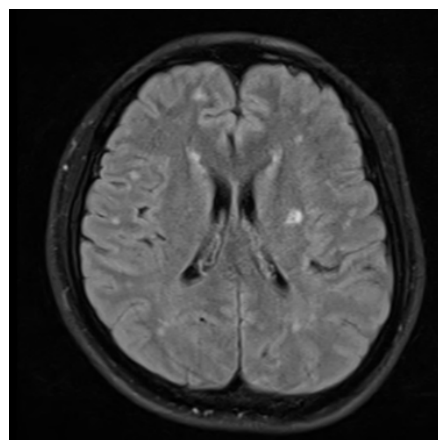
MRI Brain showing multiple discrete hyperintensities.
